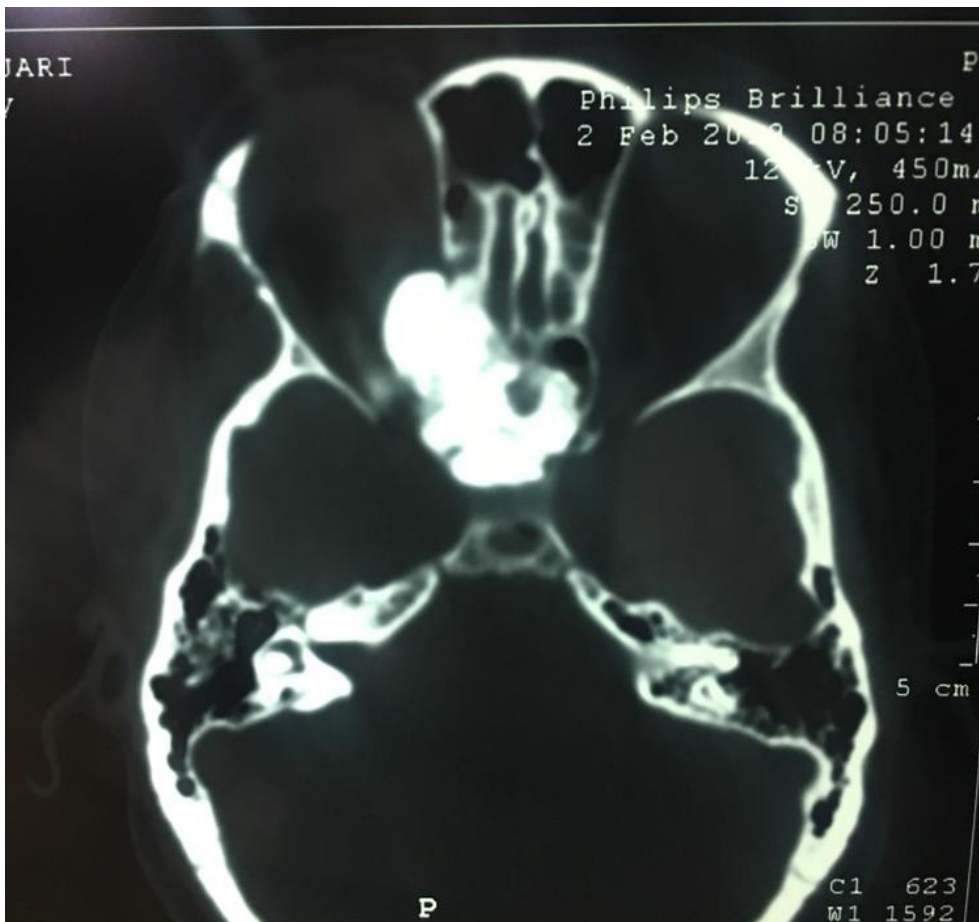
Computed tomography of face, axial cut showing a ethmoid osteoma invading the eyeball and the base of the skull and compressing the optic nerve
